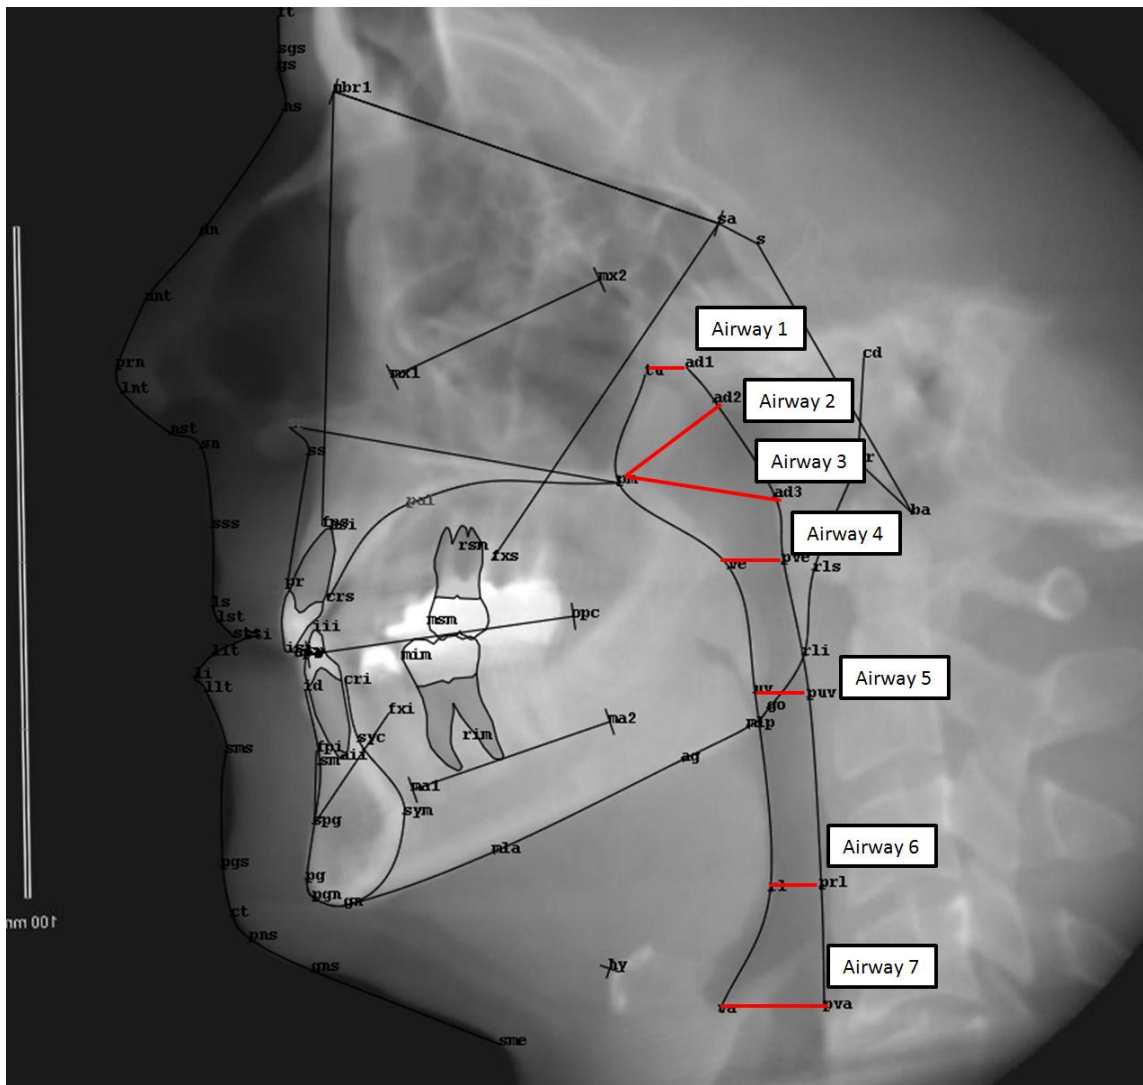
Cephalometric Analysis. Example of a cephalogram generated from a CBCT scan of a 'high-risk' male orthodontic patient. The ceph was imported into TIOPS, traced and digitized. The measurements were made by the 'AirWayMes' ysis. Digitized are 72 landmarks and 22 measurements including 7 airway measurements.
